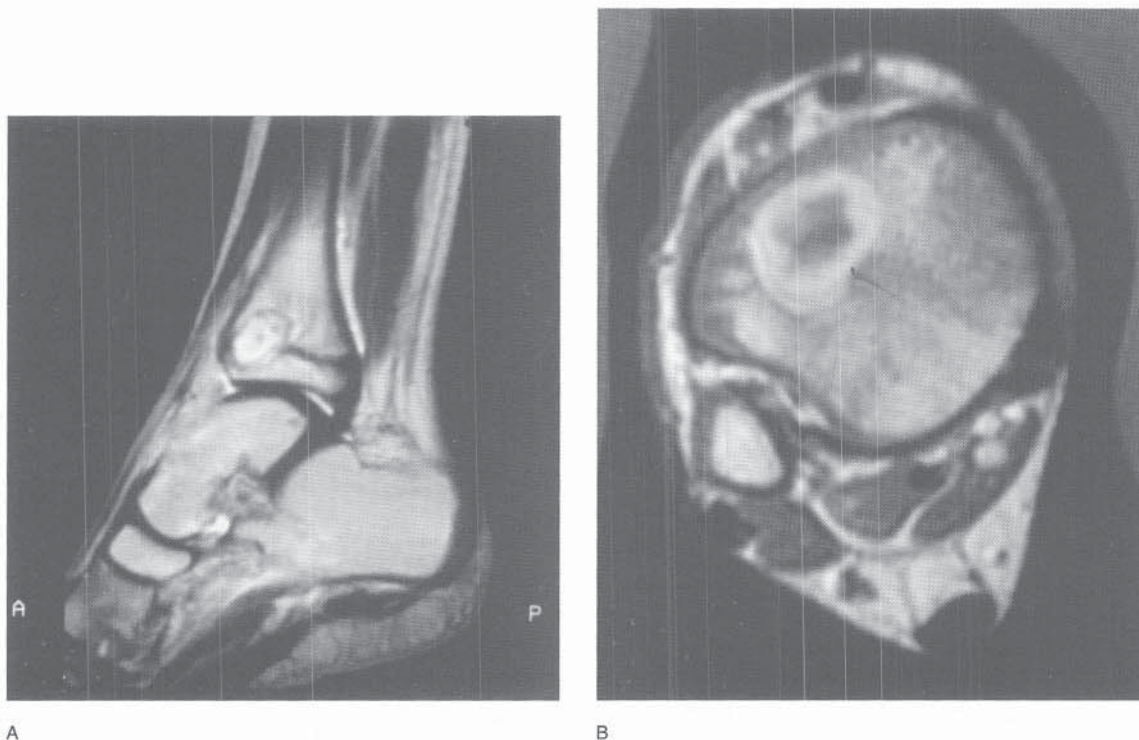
Imaging findings in a 9-year-old boy with a 3-month history of dull, aching ankle pain. Plain films revealed a lucent region in the distal tibial metaphysis and epiphysis. A, A sagittal T2-weighted image accurately localized a high-signal-intensity lesion spanning the growth plate. B, A transaxial postgadolinium image of the distal tibial growth plate demonstrated peripheral enhancement with a nonperfused region centrally suggesting an intramedullary abscess. A Brodie's abscess was confirmed at surgery.
